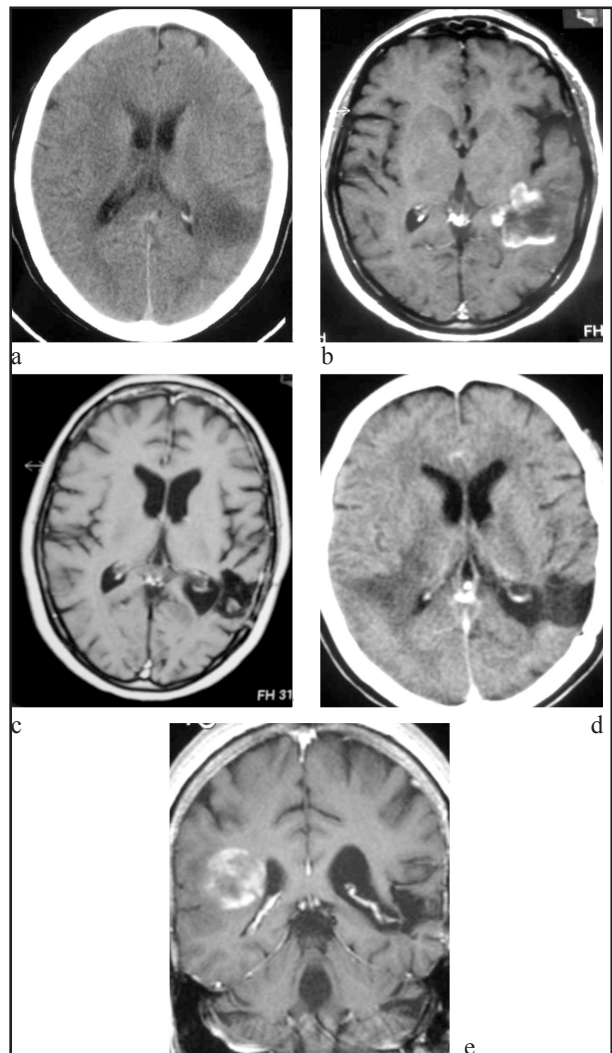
a. Axial CT image revealed a hypodense left temporal-occipital mass in the cerebral parenchyma. b. Axial contrast-enhanced T1- weighted image revealed a left temporal-occipital mass in the cerebral parenchyma with non-homogeneous, peripheral annular enhancement (open ring sign). c. Axial contrastenhanced T1- weighted image after the surgical removal of the mass where appears the craniotomy and the gliosis of brain respectively. d, e. Axial CT image and coronal contrastenhanced T1- weighted image revealed a second mass in opposite hemisphere with the same characteristics (open ring sign) of the first lesion.
